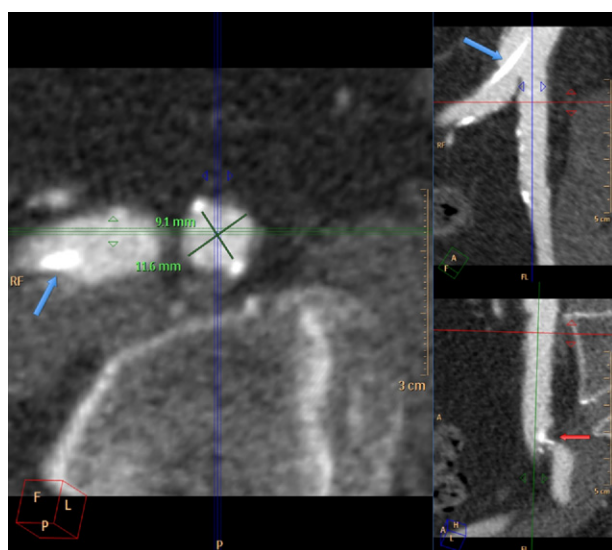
Intra-Arterial CT Angiogram
